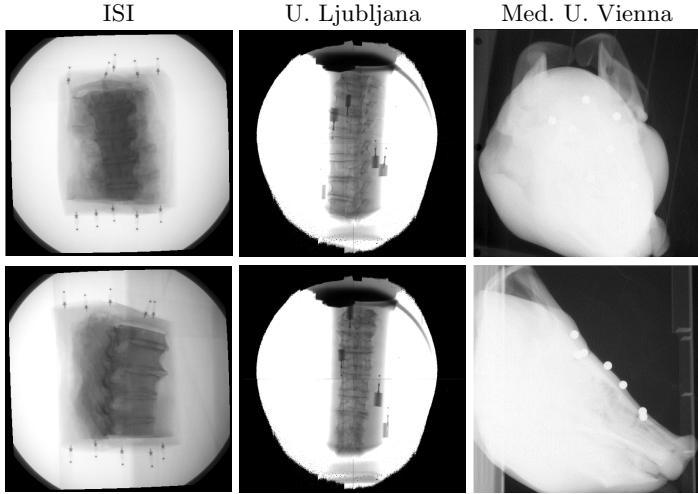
X-ray images of the reference data sets. First row: AP view. Second row: lateral view.
